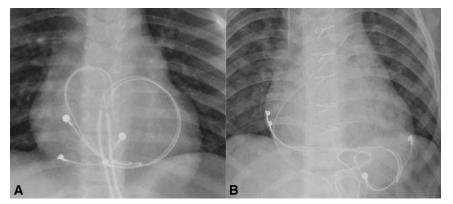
A, The last posteroanterior chest radiograph of patient 1, confirming the diagnosis of CS, showing a classic pattern of posterior looping by the atrial and ventricular leads. B, Posteroanterior chest radiograph post–lead replacement, showing patient 1 clear of any possible CS with the leads well situated at the bottom of the pericardium.
